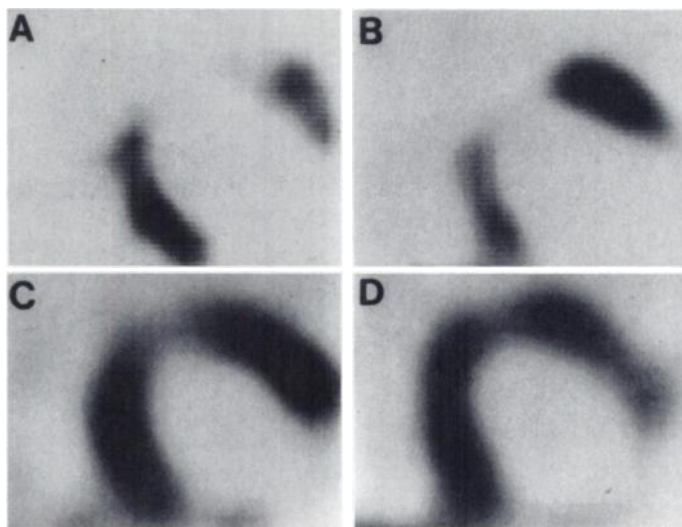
SPECT imaging of the heart in vivo (short axis-slices of the mid left ventricle). Perfusion defect in the anterior wall: (A) ^{201}Tl redistribution. (B) $^{99\text{m}}\text{Tc}$ -sestamibi. (C) Reduced but relevant [^{123}I]PHIPA 3-10 uptake in the anterior wall indicating residual viable myocardium. (D) Improved perfusion with $^{99\text{m}}\text{Tc}$ -sestamibi in the anterior wall after CABG. (A–D) Matched defect posterolateral representing scar.
